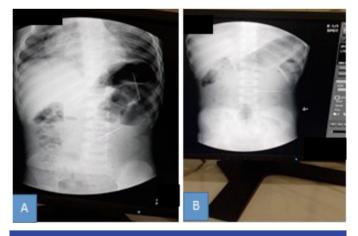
(A) X-ray taken at admission, B) X-ray on day 5
